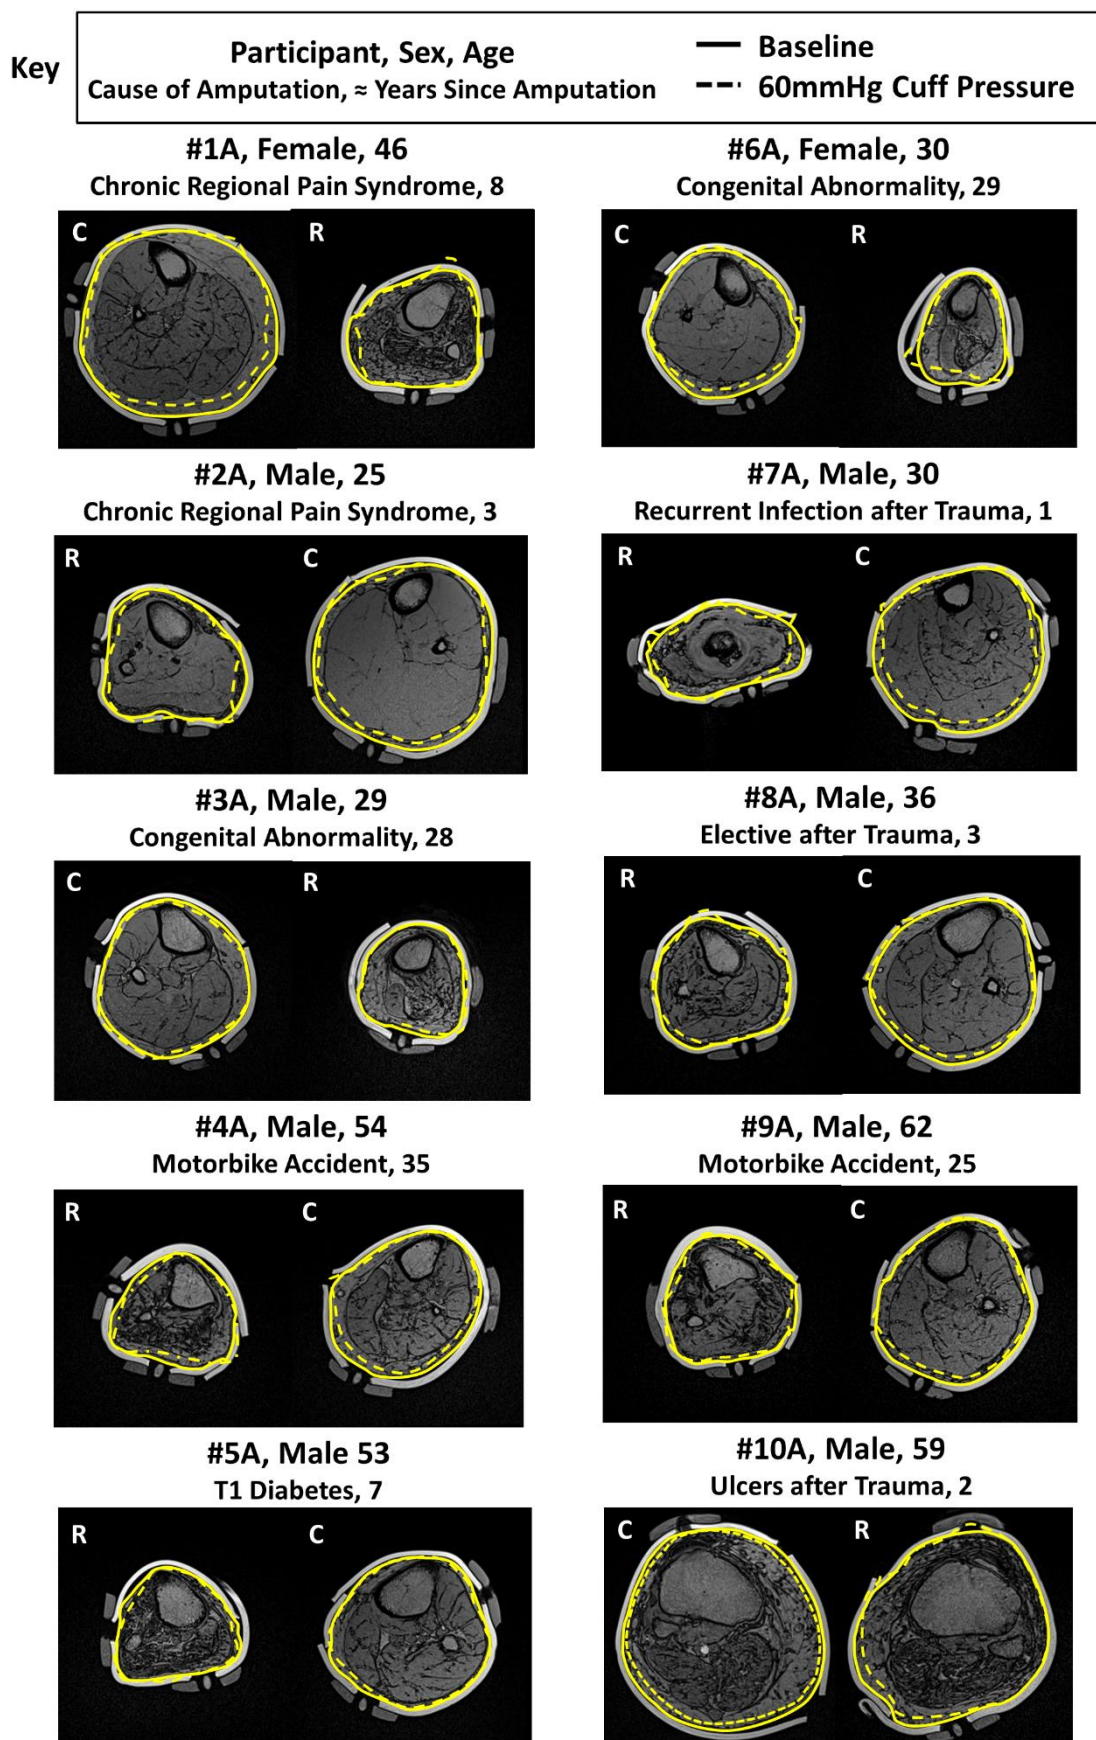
Transverse MRI slices at posterior calf measurement level at baseline outlining soft tissue at baseline (solid yellow line) and soft tissue under 60 mmHg cuff pressure (dashed yellow line), for participants with unilateral transtibial amputation (Note: #5A only pressurised to 40 mmHg)
